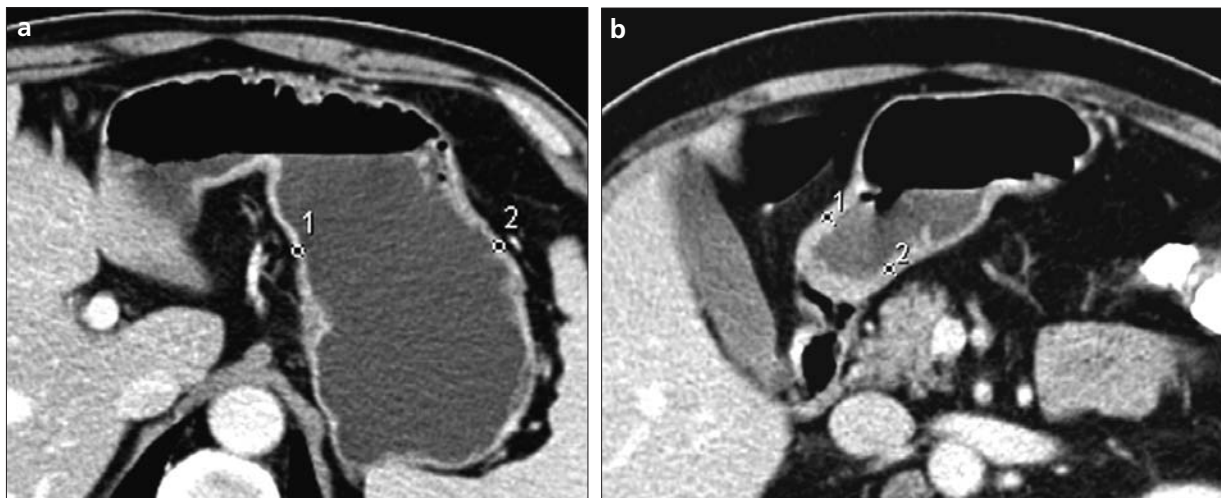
a, b. CT images show the sites of measurements for lesser (1) and greater curvature (2) wall thicknesses of the gastric body (a) and the gastric antrum (b).
